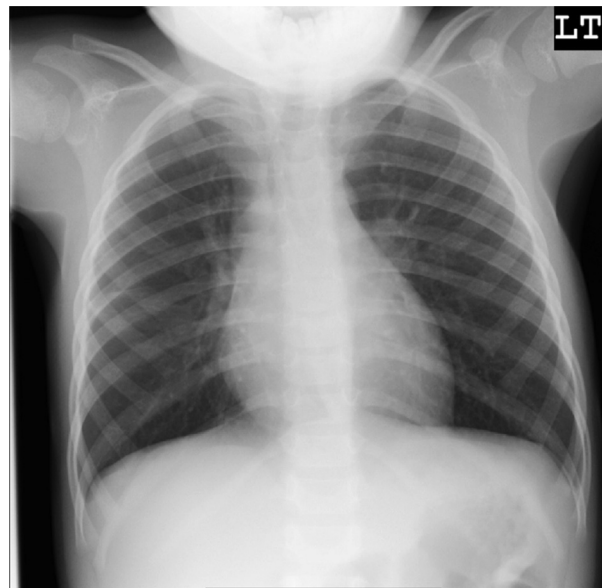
Inspiratory chest X-ray of a child with suspected foreign body. No particular change is evident.
